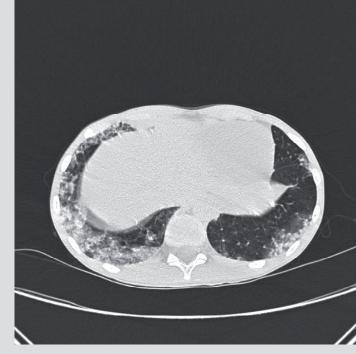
Chest computed tomography revealing bilateral pulmonary infiltrates with lower lobe predominance, peripheral consolidations and some pericardial effusion
